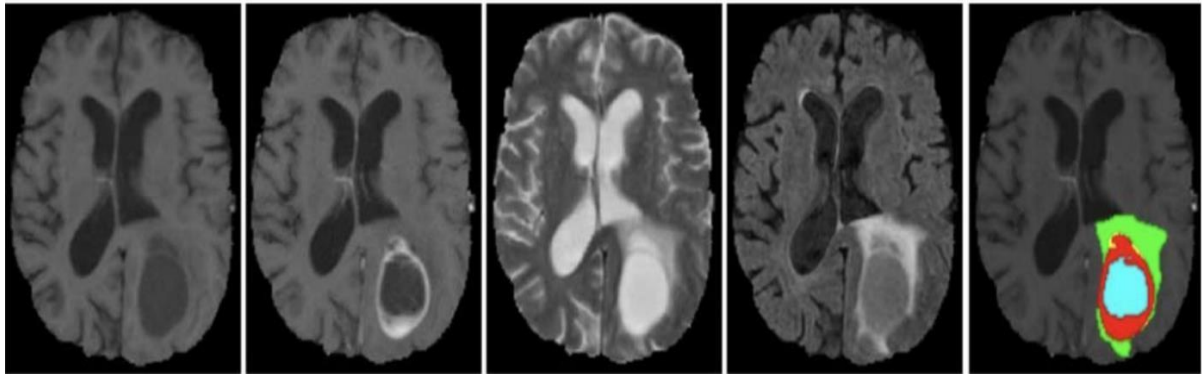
before and After Segmentation of Brain MRI images
